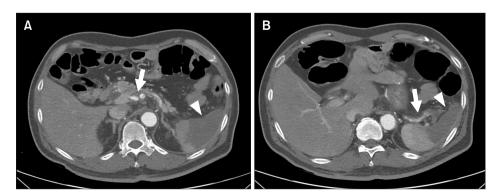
Computed tomography scan acquired 1 week later revealed (A) no progression of dissection in the celiac, common hepatic, and (B) splenic arteries, along with a decrease in intraluminal hematoma (arrows). The extent of splenic infarction slightly increased (arrowheads).
